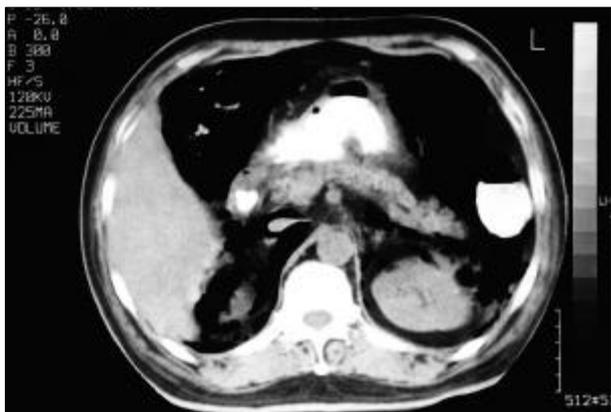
CT scan shows abnormal gas collections in the peritoneum and retroperitoneum and throughout the bowel wall (width 400, level +20).
